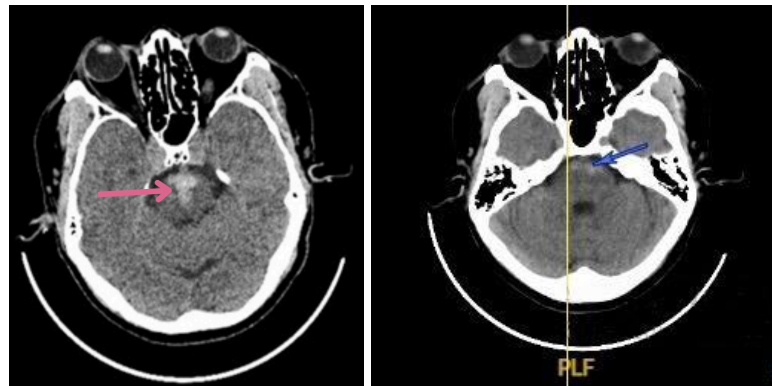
Non-contrast brain CT in a 57-year-old man showing a brainstem hemorrhage (arrow)
